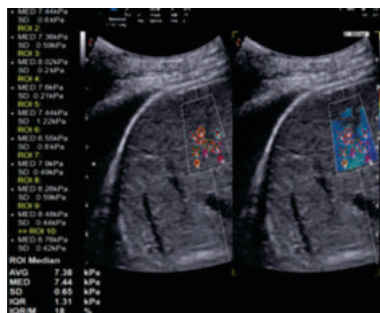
Ultrasound examination of a liver with mild steatosis, as
